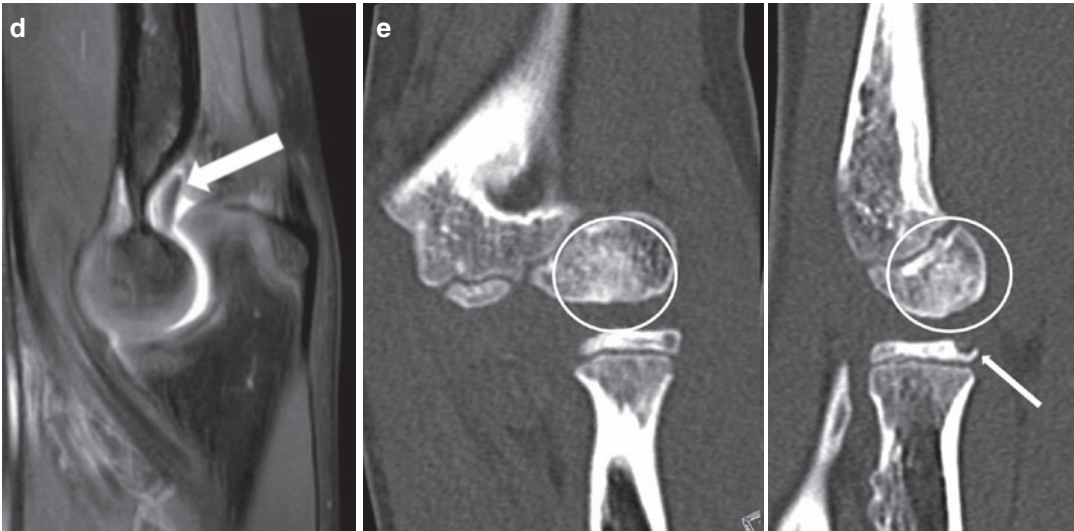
A 15-year-old gymnast with right elbow pain. AP and lateral radiographs of the right elbow. On the lateral view the lucency in the capitellum (black arrowheads) is compatible with an osteochondral defect. The lesion is much more difficult to appreciate on the AP view; it is discriminated because of the surrounding faint sclerosis (black arrows)
